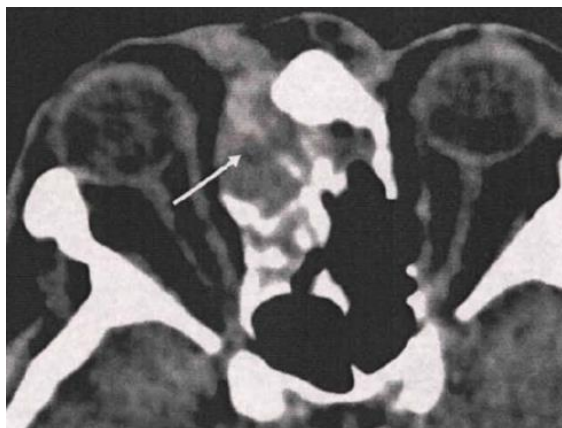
Patient N., 62 years old, fragment of a computed tomography scan. The cells of the ethmoid labyrinth on the right are visualized, a formation extending into the right orbital cavity is visualized, the orbital wall is destroyed.
